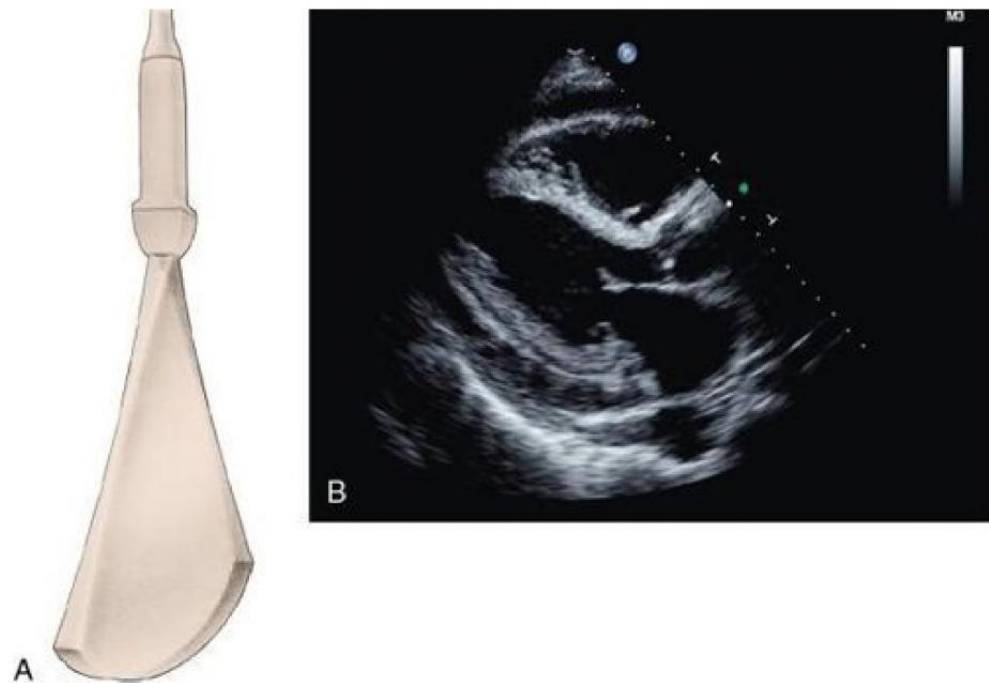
A, Ultrasound sent through a thin pie-slice-shaped volume of tissue produces an image commonly called a *sector image* or *sector scan*. B, Sector scan of adult heart.
